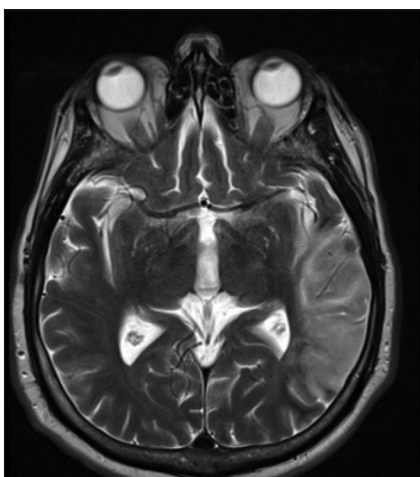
T2-weighted MRI images with ischemic changes in the left temporal lobe.
